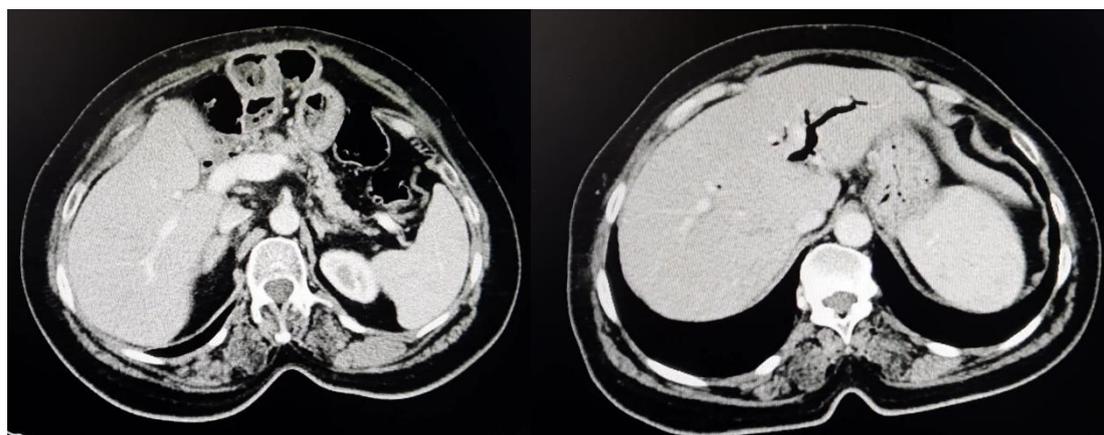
Control MRI after surgery showing a fatty degenerating pancreas of normal morphology with no scannodecelar lesion.
